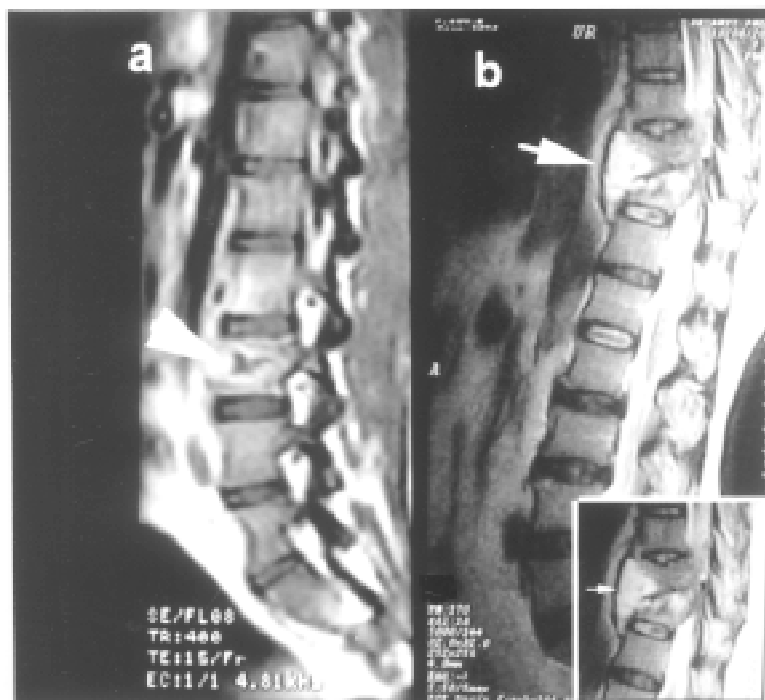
Magnetic resonance imaging (MRI) scan of the dorsolumbar spine, (sagittal view, T1 weighted image) showing central hypointense lesion (arrow) with reduced vertical height of the vertebra (a). MRI scan of the dorsolumbar spine (sagittal view, T2 weighted image) showing destruction of D10 and D11 vertebrae (arrow), reduction in the intervening disc (inset, arrow) with anterior granulation tissue and cord compression (b).
